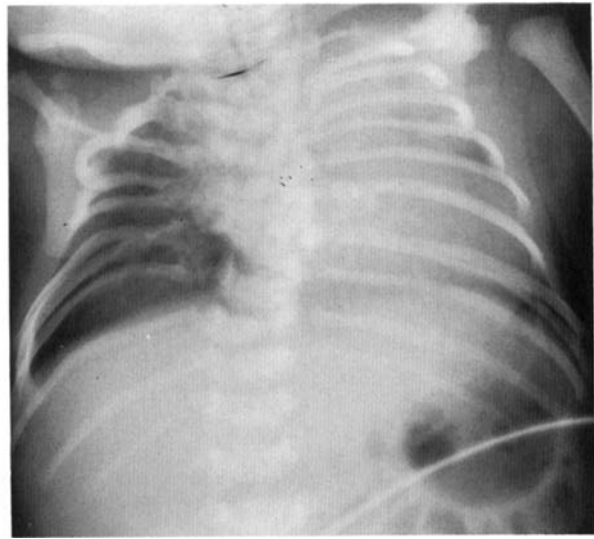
Anteroposterior radiographic film of the thorax of patient 23. The seventh and eighth rib on the left side are partially fused (cervical rib on the left side). The right hemithorax is more severely affected with fusion of multiple ribs at the costovertebral ends.
